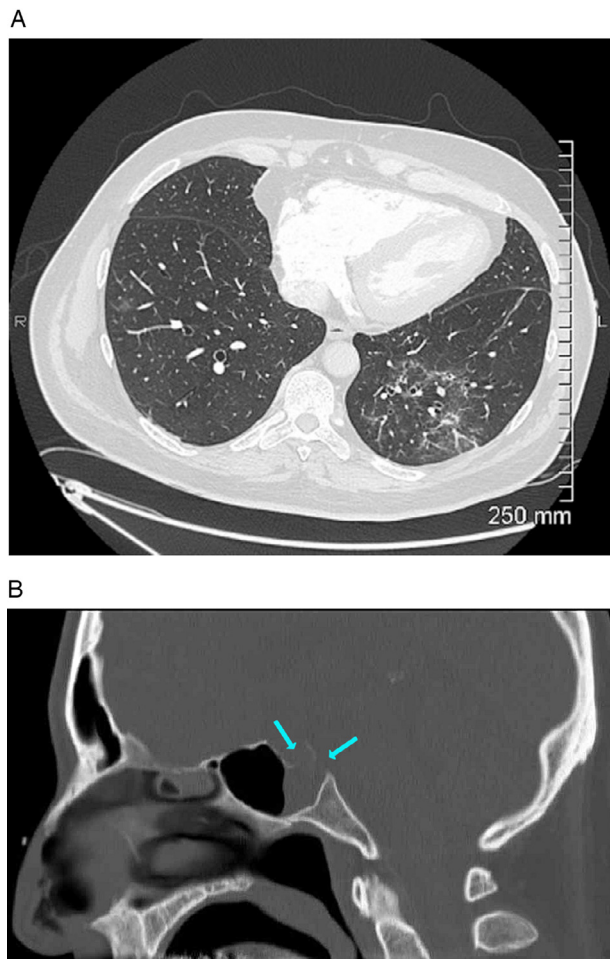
(A) Axial computed tomography of the thorax with contrast showing patchy consolidative and ground glass changes in the dependent lung zones. (B) Sagittal computed tomography of the head showing (blue arrows) defect in the floor of the sella and in the upper clivus and posterior wall of the sphenoid sinus caused by the pituitary macroadenoma.
